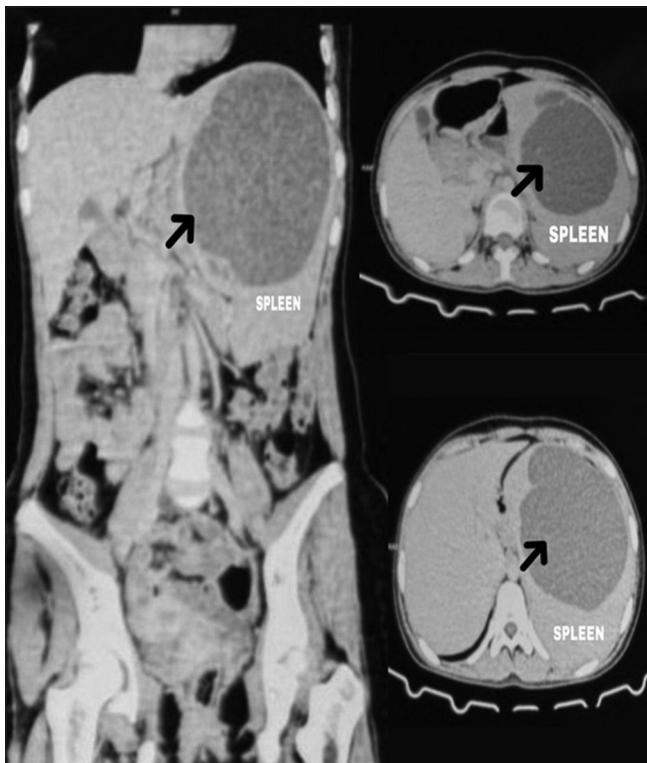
Contrast-enhanced computed tomogram abdominal scan showing a huge splenic cyst displacing stomach and kidney (transverse section). Arrow indicated huge splenic cyst in CT imaging
